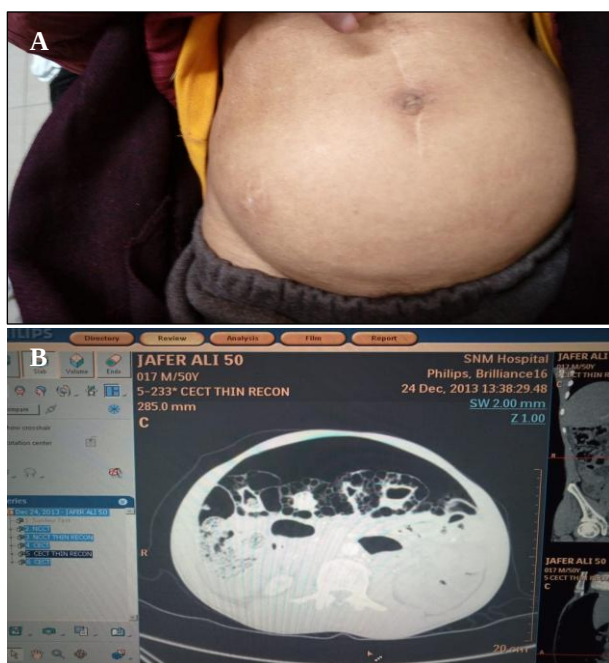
A) Pneumotosis intestinalis: Gross distension of gaseous distension of abdomen due to free air arising due to rupture of air filled bulla, B) CT Abdomen finding of pneumoperitoneum and air filled cyst and bullae in the intestinal wall
